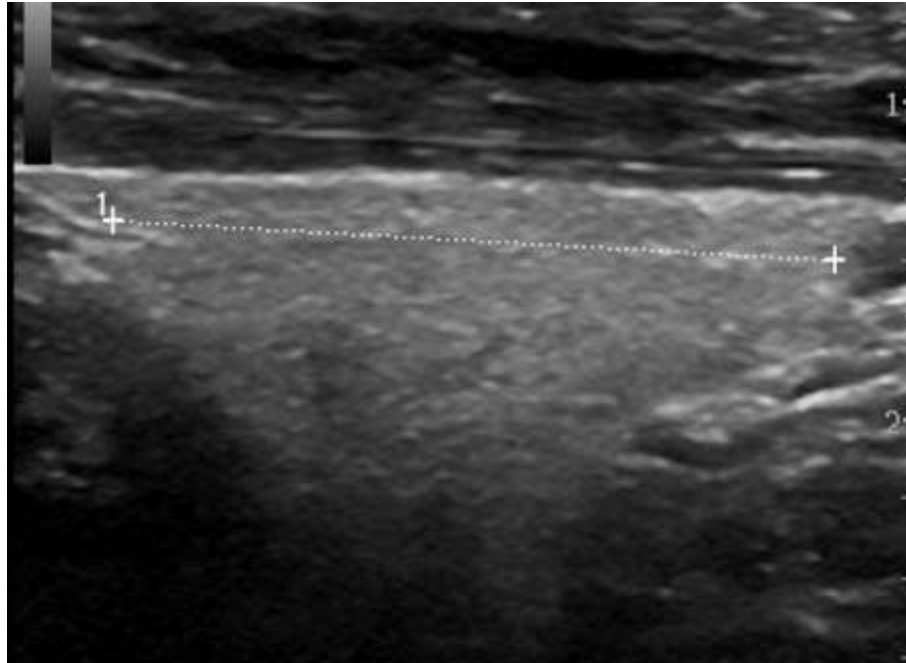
Longitudinal Scan sonogram showing measurement of the craniocaudal dimension (caliper 1) of the right lobe of a thyroid gland (Malago et al., 2008).
